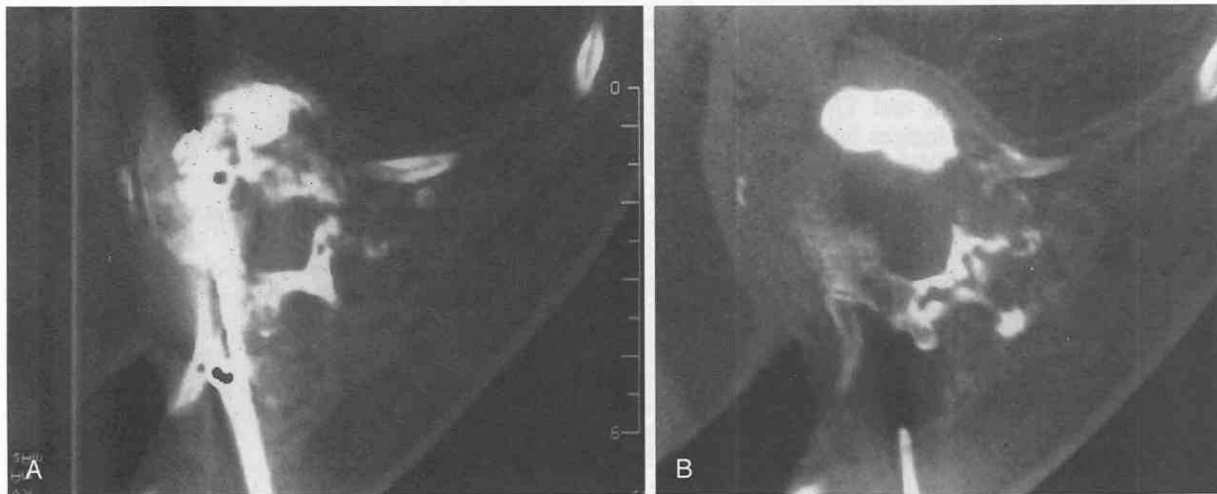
A, Axial CT image with needle in place through the pedicle of a metastatic vertebral body during percutaneous vertebroplasty. B, Axial CT image after injection of polymethylmethacrylate cement.
